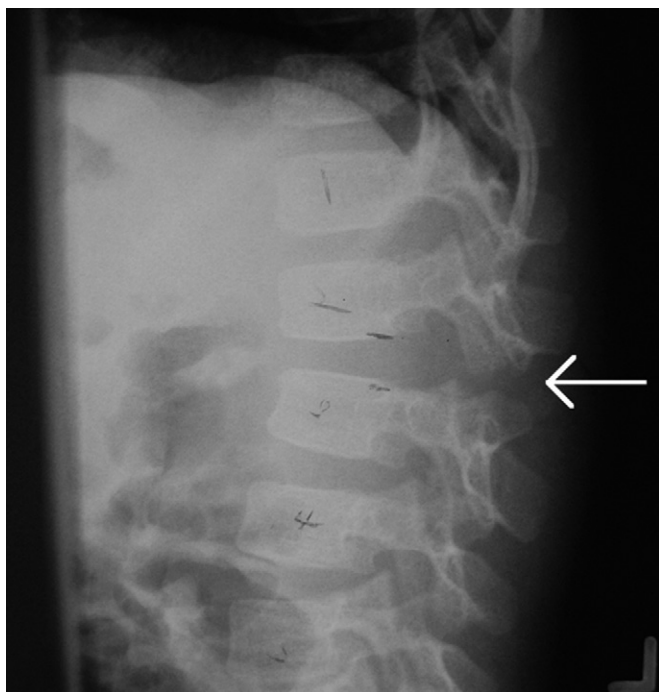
Plain lateral lumbar spine radiograph. Arrow indicates distraction injury to posterior spine secondary to lap belt injury.
